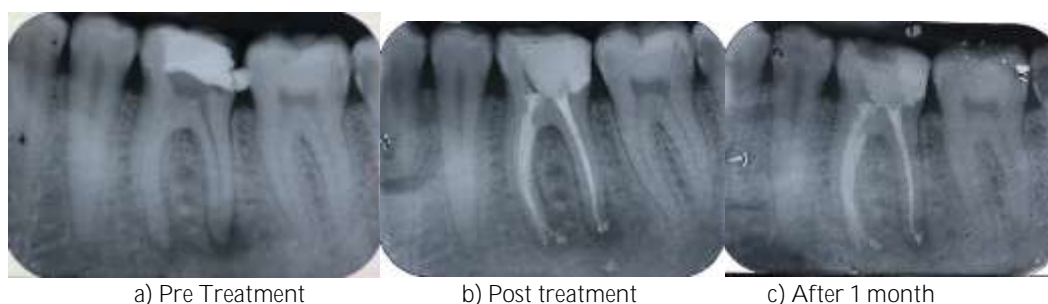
Radiographic films showing the roots of tooth #36. a) preoperative radiograph present a periapical lesion for both roots b)The mesial and distal roots were obturated with Gutta-core X2 andX3 respectively and AH Plus sealar. c,d,e) reveals the healing of the lesions at 1 month, 3 months, and 6 months after minimally invasive Endodontics therapy using Er,Cr:YSGG laser.
